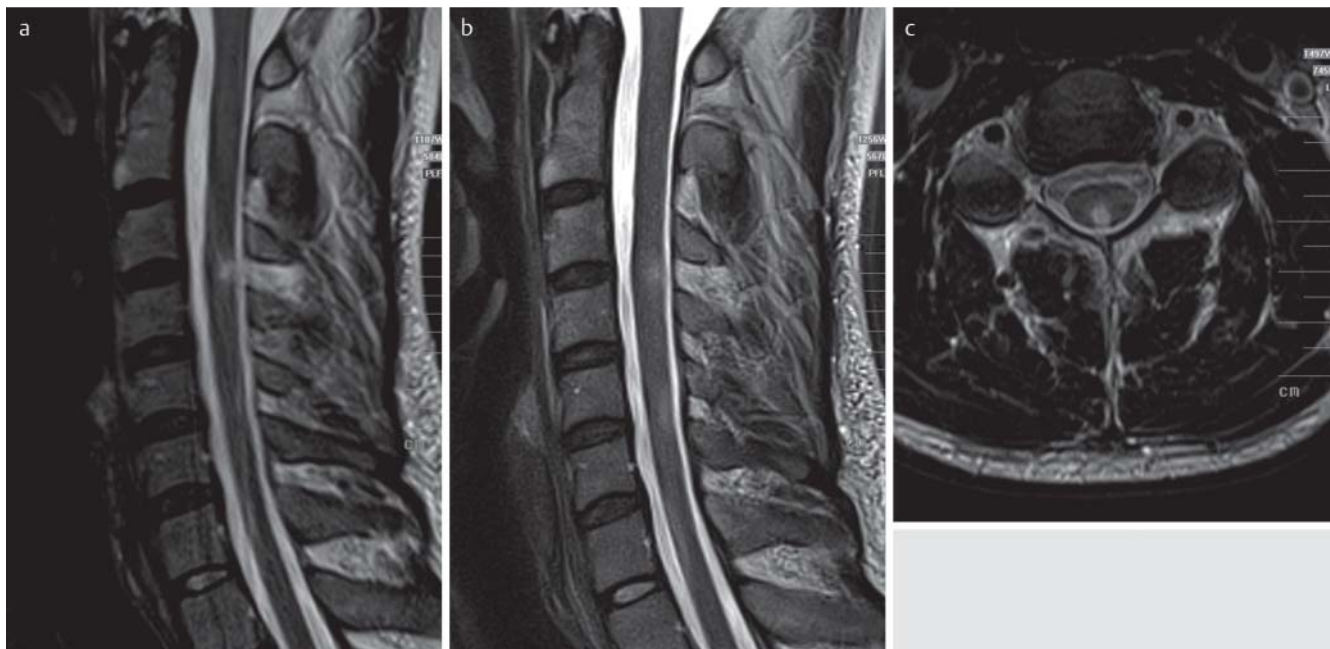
Sagittal T2-weighted TSE a shows significant artifacts with reduced image sharpness and spinal cord depiction. A dorsal midline lesion at level C3/4 is misjudged in sagittal T2 TSE a as artificial but is clearly confirmed in BLADE b and axial T2 c. Furthermore, additional lesions at level C5/6 and C7 can be identified in BLADE and on axial T2 (not shown).
